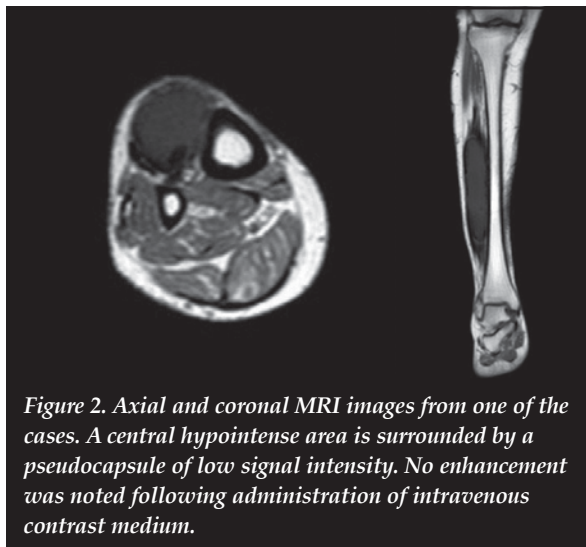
Axial and coronal MRI images from one of the cases. A central hypointense area is surrounded by a pseudocapsule of low signal intensity. No enhancement was noted following administration of intravenous contrast medium.
